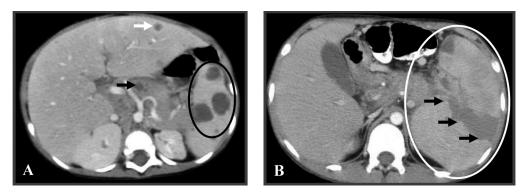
Splenic involvement. Fig. 4 A is an axial CT image demonstrating liver abscesses (encircled. Incidentally, there is also a small nodule in the liver (white arrow) and in the pancreas (black arrow). Fig. 4 B is an axial CT scan image demonstrating an enlarged spleen (encircled) with a large area of infarction (arrows).
